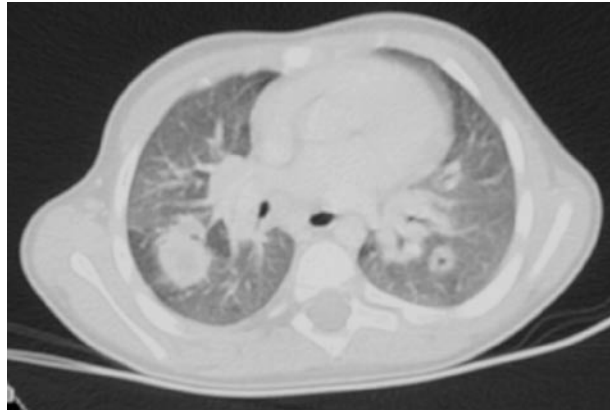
Computed tomography scan of the thorax demonstrating bilateral nodular and cavitary disease.
